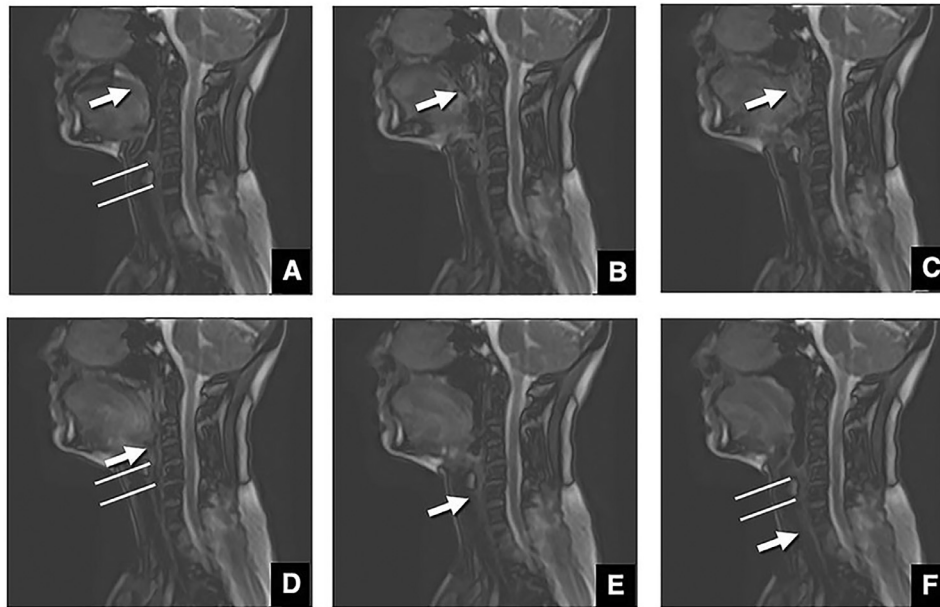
A low-quality swallowing series in the midsagittal plane on cine-magnetic resonance imaging (CMRI) performed after surgery in a 51-year-old woman with right tongue cancer. A, Oropharyngeal closure (1.61 seconds). B, Velopharyngeal closure (passavant ridge 1) (2.43 seconds). C, Glottal closure (2.57 seconds). D, Esophageal opening (passavant ridge 2) (2.71 seconds). E, Esophageal closure (3.21 seconds). F, Glottal reopening (3.50 seconds). The flow direction to the esophagus can be evaluated. The majority of structures in this case with low-quality images are not clearly visible because the images are not sharp; the images are blurry because of motion artifacts caused by fast swallowing. The ascent and descent of the larynx are highlighted by double lines.
